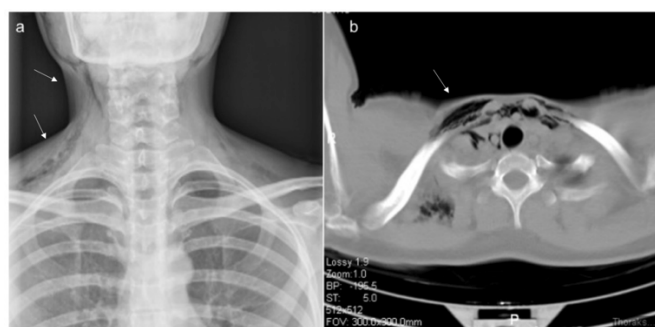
Chest x-ray showing the subcutaneous emphysema (a) and computed tomography image (b) showing the air entrapped in the superior mediastinum.
